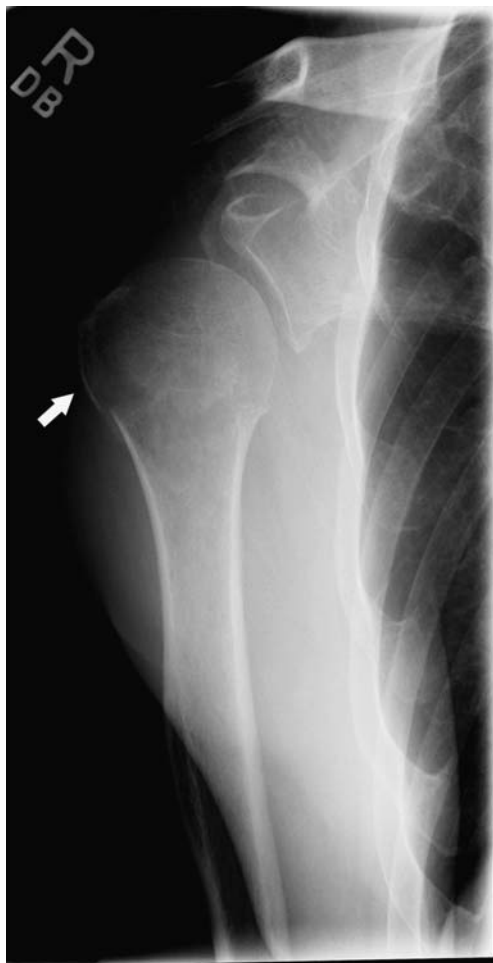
Anteroposterior radiograph demonstrating a greater tuberosity fracture (white arrow) as a result of overly aggressive manipulation of a stiff right shoulder under anesthesia.
